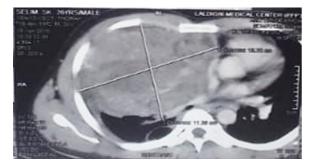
CT Thorax shows Yolk Sac tumour in a 26 years old patients
